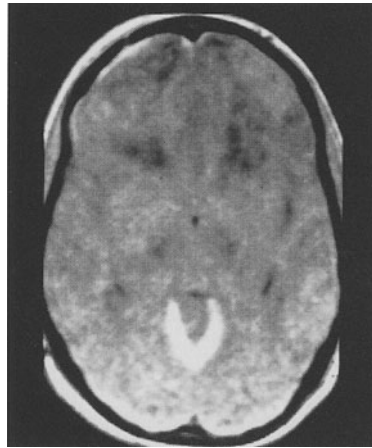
T1 (TR 68, TE 24, FA 60) open-design, low-field MRI examination demonstrating acute SAH as markedly high signal intensity. (Image obtained on a 0.64-T Toshiba open MR system)
